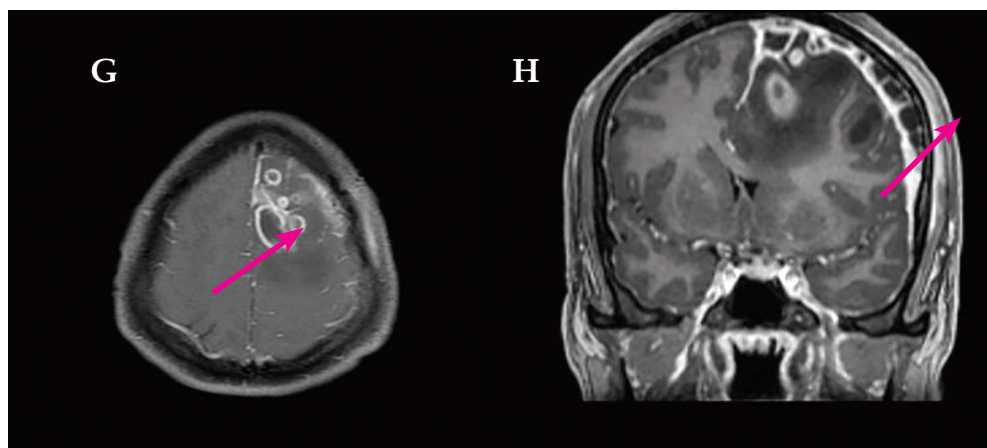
(G) MRI brain with contrast showed Conglomerate peripheral rim enhancing lesions in left frontal lobe, (H) Multiloculated extra-axial collection with dural enhancement
